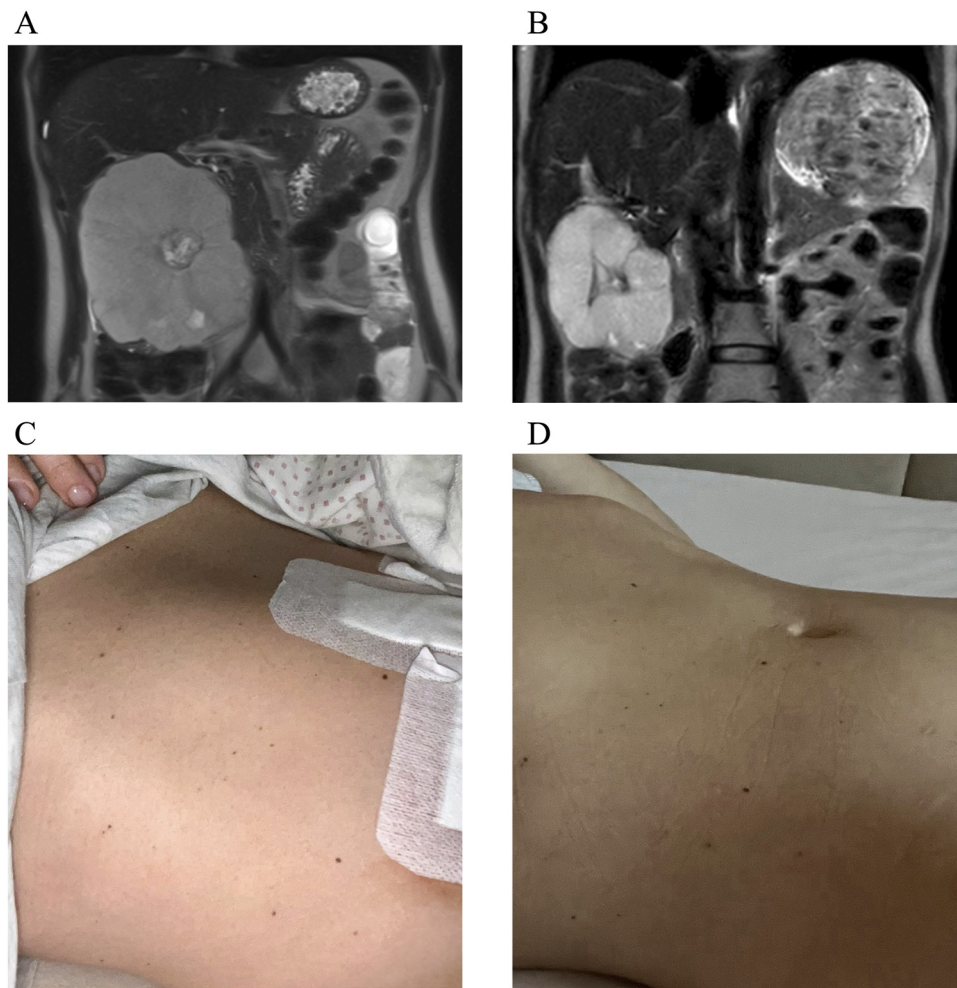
Panel A shows coronal T2 MRI image of the giant haemangioma prior to the TACE treatments. Panel B shows coronal T2 MRI image 6 months after the second TACE. Panel C shows bulging of the haemangioma in supine position, while panel D demonstrates the cosmetic results six months after the last treatment
